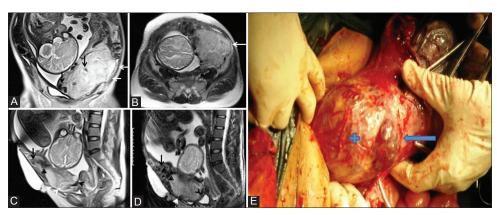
(A-E): Low-lying anterior placenta percreta in a 32-year-old woman at 34 weeks of gestation. (A, B) Coronal and axial T2 HASTE MR images show a heterogeneous placenta with thick, dark intraplacental bands (black arrows). Focal interruption of the left inferolateral myometrium and subserosal extension of placental tissue (white arrows). (C, D) Sagittal T2 HASTE and T2 fast spin echo (FSE) MR images show focal interruption of anterior myometrium (black arrowheads), anterosuperior to the internal os and extending subserosally (white arrowheads). Marked heterogeneity of the anterior myometrium, just superior to the invasion noted, represents abnormal vascularity (arrow). (E) Surgical photograph showing the placenta extending through uterine wall (+) and covered by thin serosal layer (arrow). No features of bladder invasion
